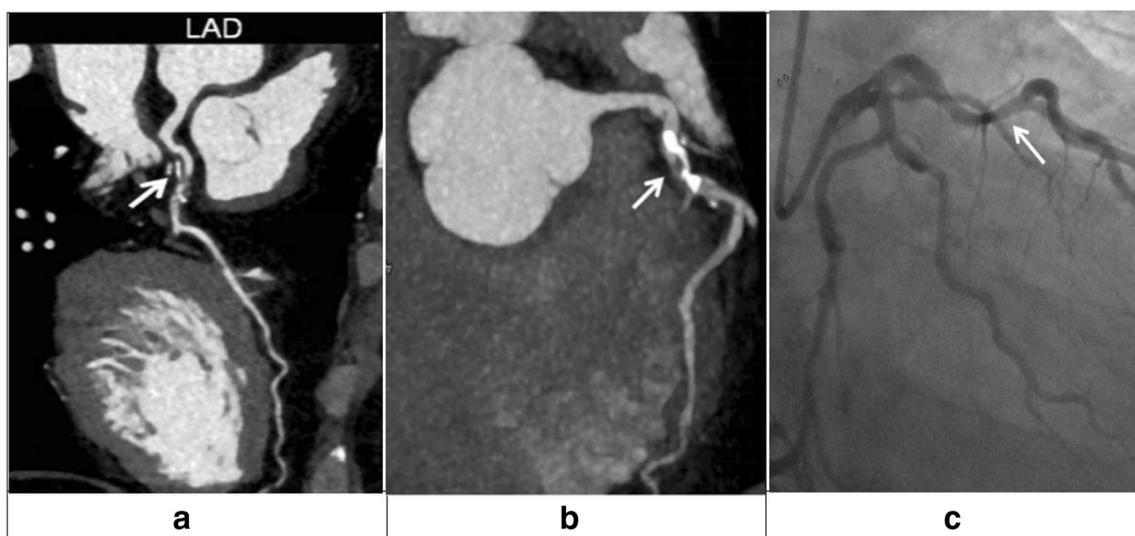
Turbo high-pitch coronary computed tomography angiography and invasive coronary angiography for a 59-year-old man with chest pain (mean heart rate = 50, body mass index = 26.26, effective radiation dose = 0.37). The curved planar reconstruction image in a and the maximum
